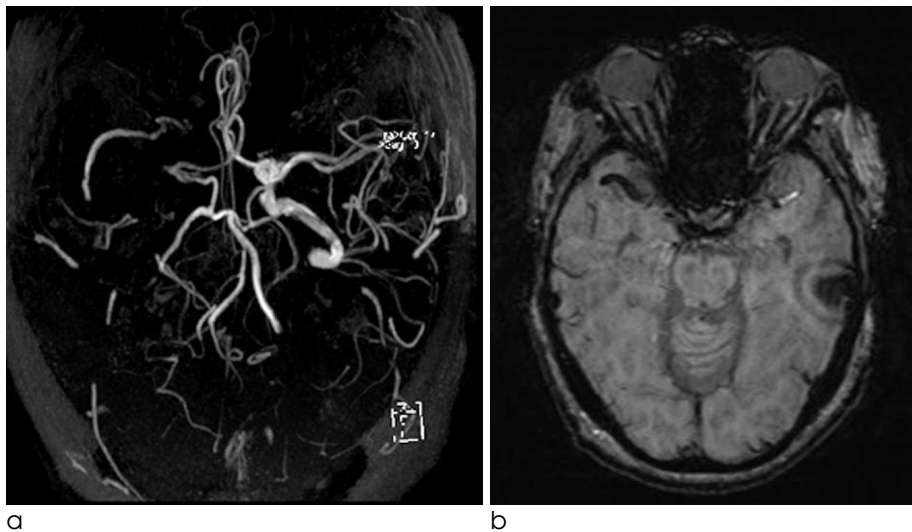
Arterial blooming. 3-dimensional time-of-flight MRA (a) shows occlusion of right middle cerebral arteries. Dark signal intensity of clot in right middle cerebral artery is demonstrated on susceptibility-weighted MR image (b). The susceptibility effect, attributed to clot deoxyhemoglobin content, exceeds the true MCA diameter.
